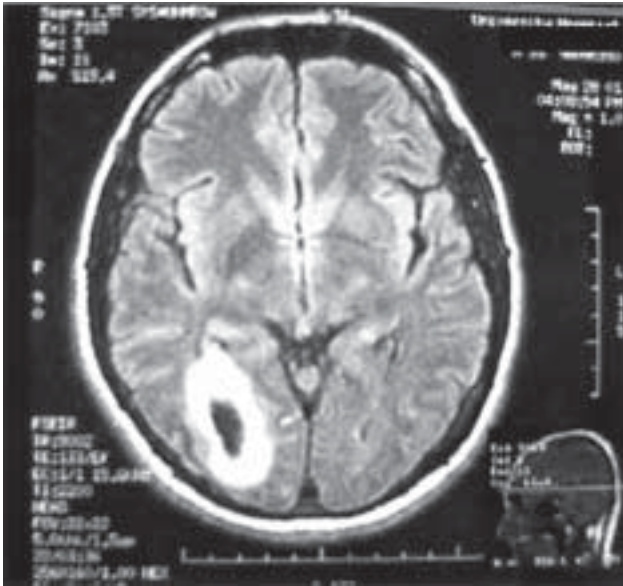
Axial, non-contrast, FLAIR (Fluid Attenuated Inversion Recovery) magnetic resonance image. Ring-shaped lesion in the right occipital lobe represents an abscess. The hyperintense signal ring represents vasogenic edema within the white matter and may also contain abscess wall. The dark central area of the lesion represents fluid or purulent material within the abscess.
